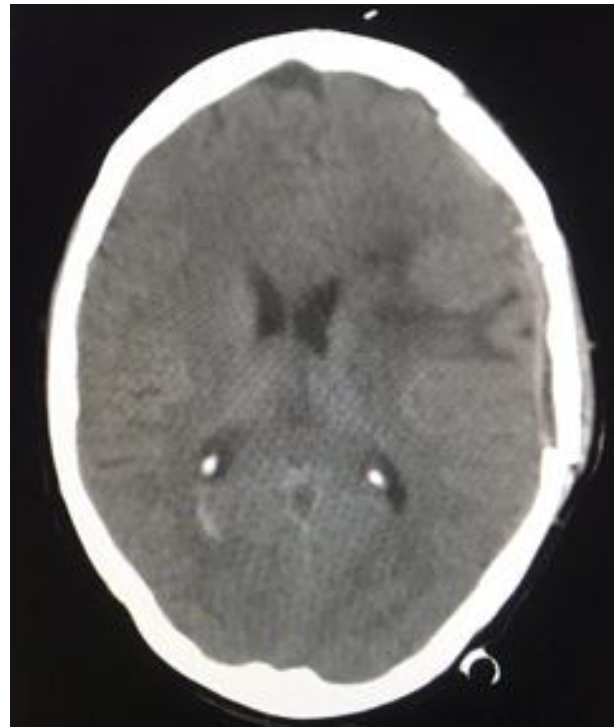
A non-contrast post-operative axial CT scan showing complete evacuation of the intracranial and intraventricular haemorrhages with a significant decrease in the midline shift.
